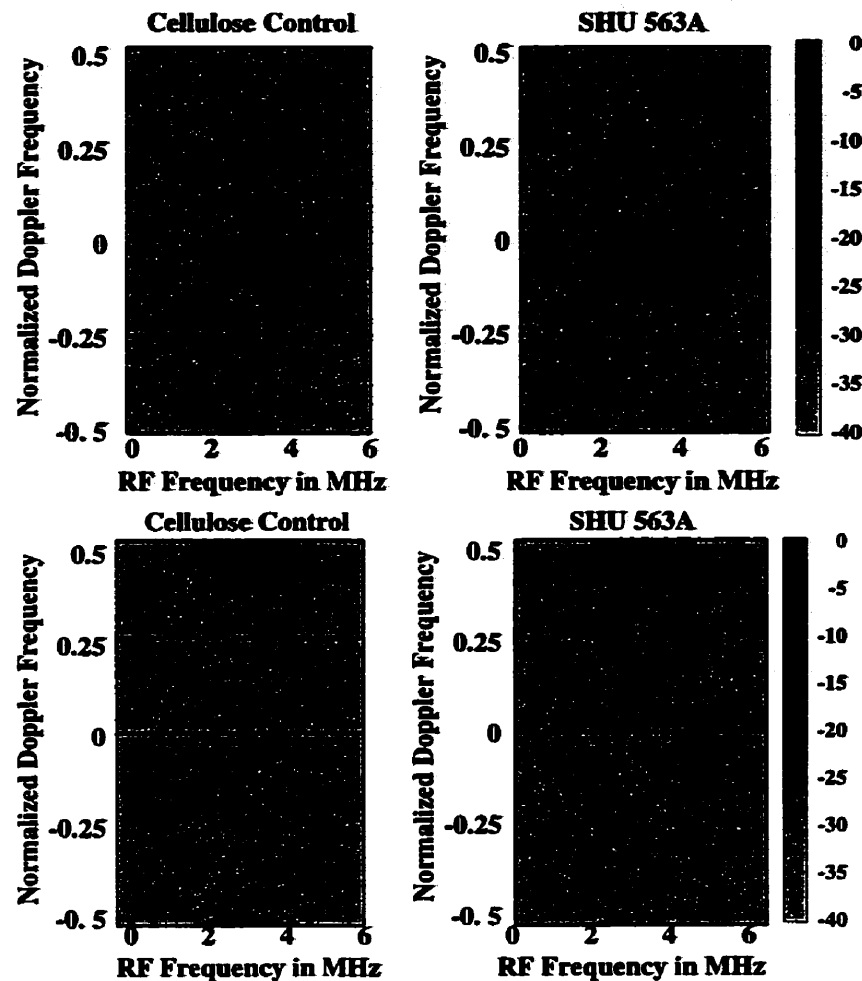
Echo power in dB as a function of Doppler and RF frequency for Narrowband Pulses: 5 cycle, 2.2 MHz, 500 kPa transmit pulsing; TOP: conventional Doppler; BOTTOM: pulse inversion Doppler. The negative half of the RF spectrum in each case (not shown) was identical to the positive half, but with inverted Doppler shifts. The beat patterns in RF frequency in the linear echo components are sidelobes due to windowing of the transmit pulses. The nonlinear signal is concentrated at the second harmonic of the transmit frequency.
